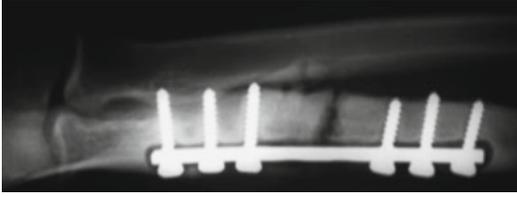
Radiograph showing osteolysis and loosening of a plate fixation due to infection
